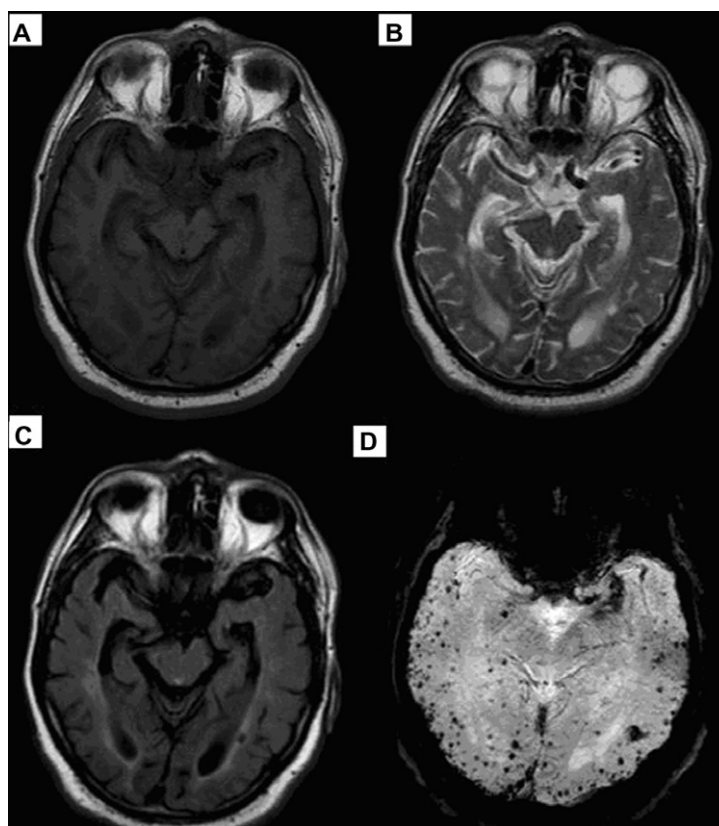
Fifty-nine year old male patient with dementia presenting with disturbed sensorium. T1 (A), T2 (B) and FLAIR (C) images show involuntional brain changes, SWI minIP(D) images reveal multiple foci of chronic microbleeds peripherally located within both cerebral hemispheres. Establishing the radiological diagnosis of cerebral amyloid angiopathy.
